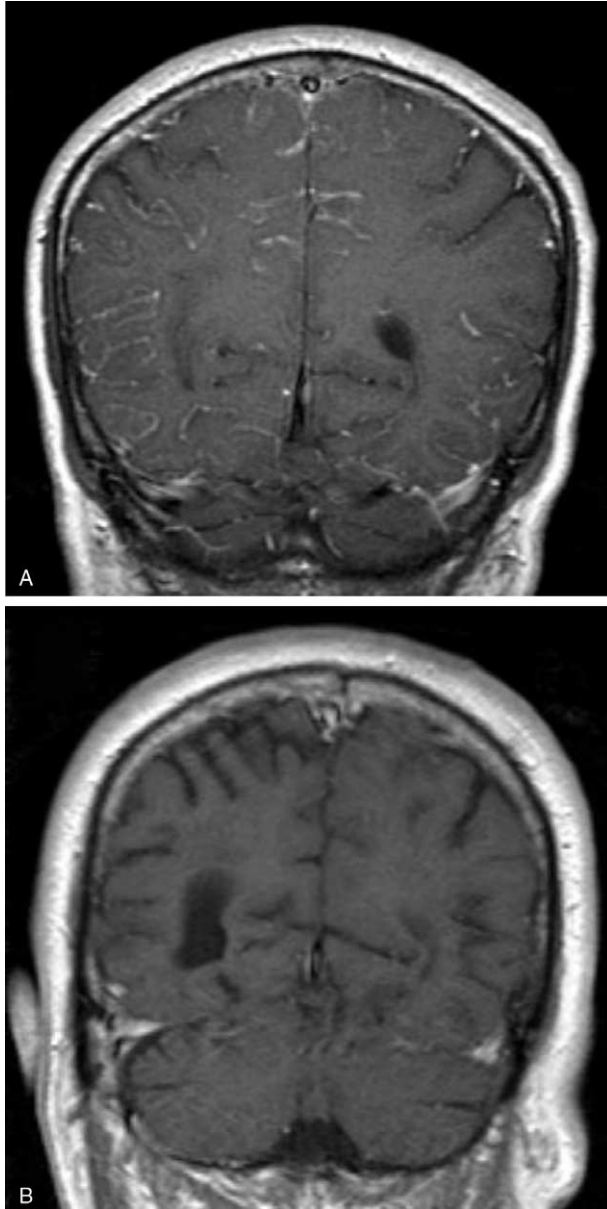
Magnetic resonance image (MRI) showing prominent leptomeningeal contrast enhancement. (A) MRI at symptom onset: diffuse, asymmetric, nodular, and linear leptomeningeal enhancement. (B) MRI after treatment: resolution of abnormal contrast enhancement and abnormal T2 signal within the sulci.
